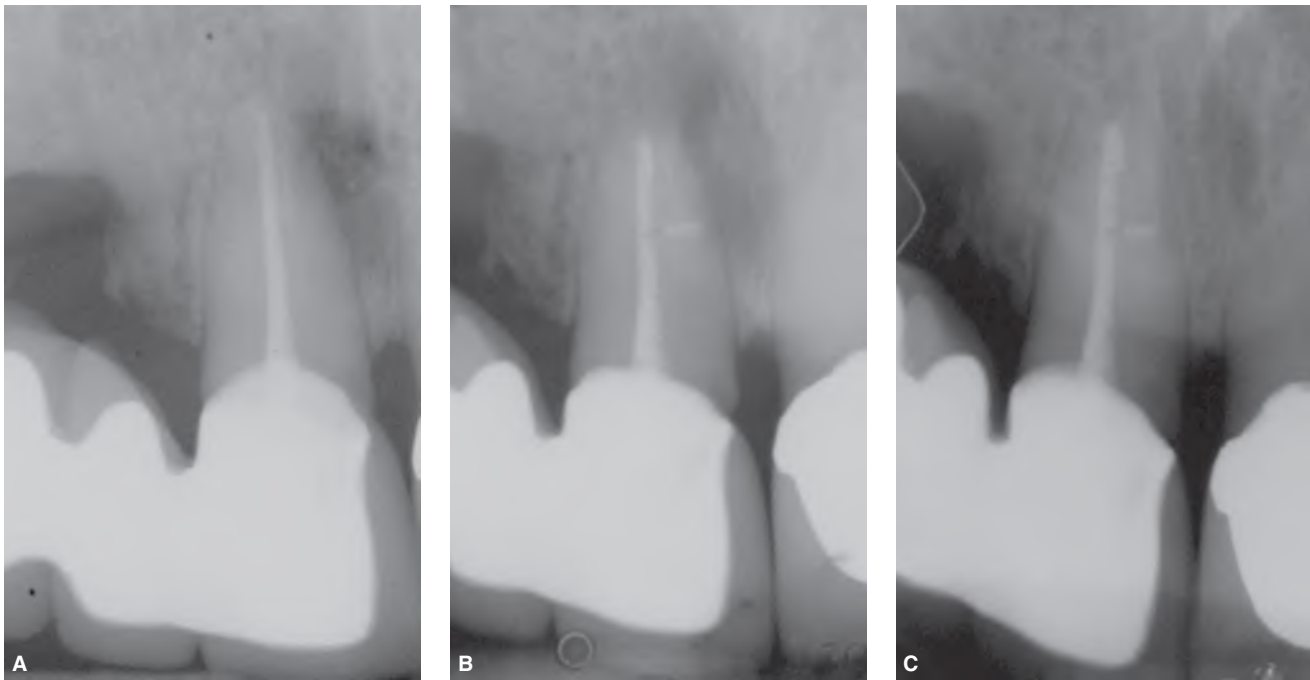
Non-surgical endodontic treatment of a maxillary central incisor with a lateral radiolucency. A. Pre-operative radiograph showing previously treated root canal with mesial lateral lesion. B. Tooth was re-treated and the root canal filled with thermoplasticized gutta-percha and sealer. Note, lateral canal extending toward the lesion. C. One-year recall shows evidence of active healing.
